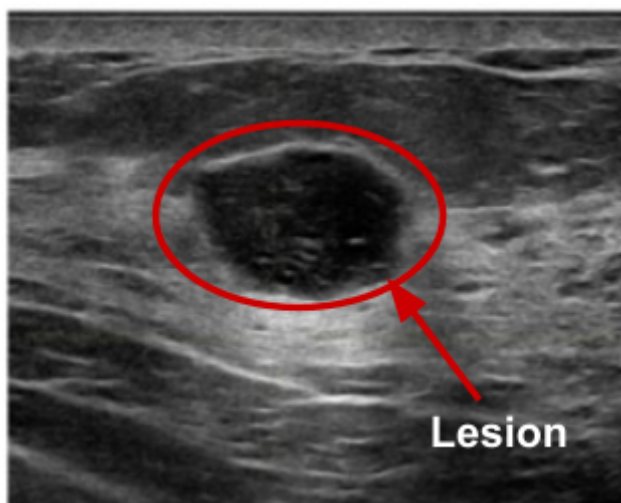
Ultrasound image where a circular breast lesion is visible, taken in B-mode.*²⁵
